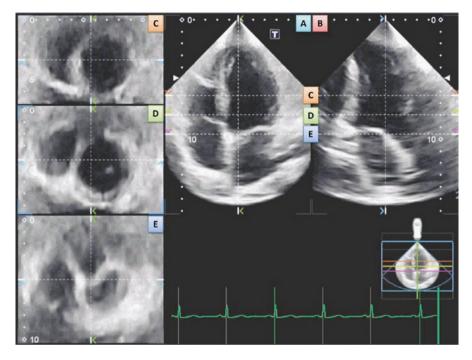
Example of a 3D echocardiography acquisition. With full volume data acquisition in real time, it is possible to obtain cines of various planes at the same time. (a) 4 chamber view; (b) 2 chamber view; (c–e) short axis views. It is remarkable to notice the ability to observe more than one plane at the same time
